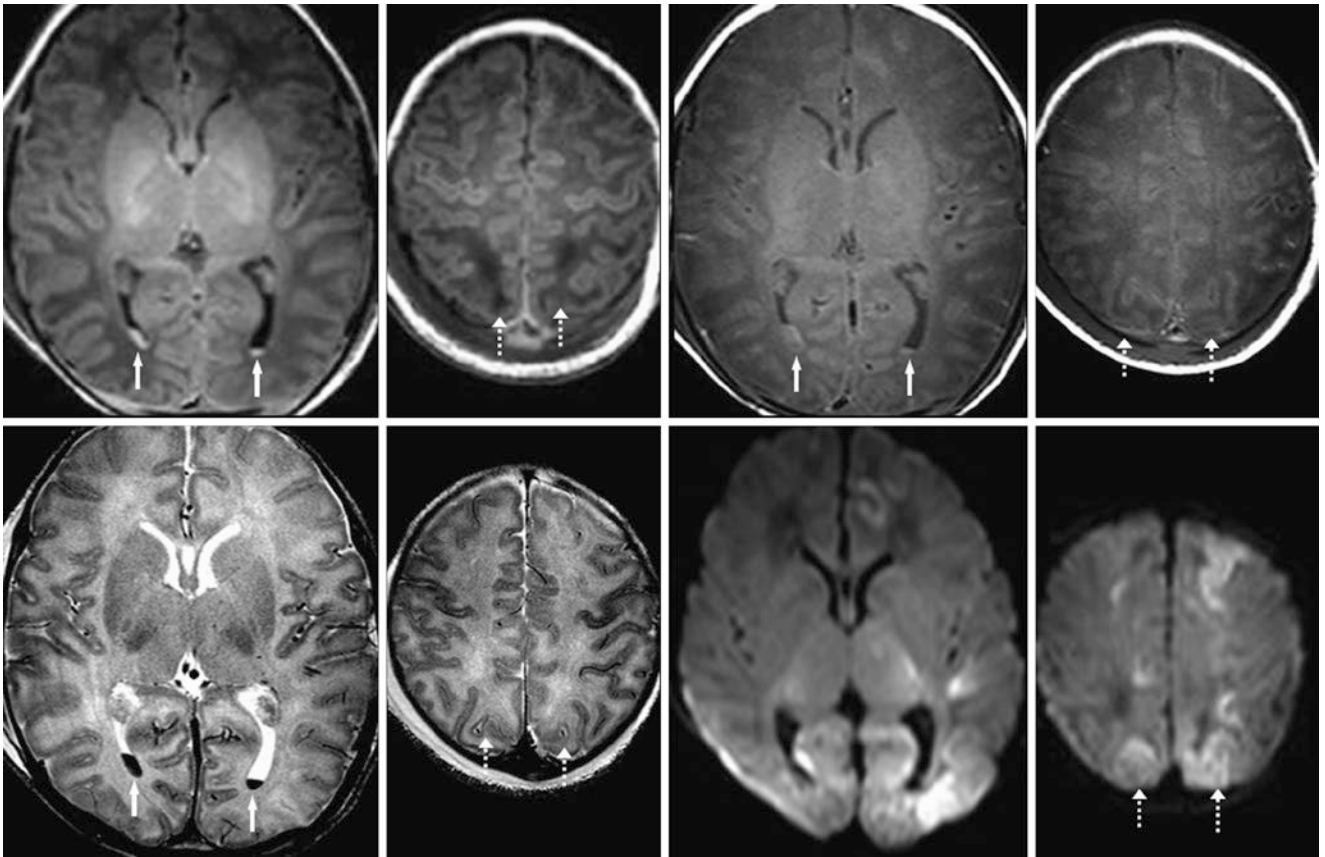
Comparison case of mild HII. A 1-day-old term neonate with prolonged seizures. *Top row:* 3T MRI with GE T1WI (*left and left middle*) showed intraventricular hemorrhage in the lateral ventricles (*arrows*), parietal edema (*dotted arrows*), and normal-appearing basal
